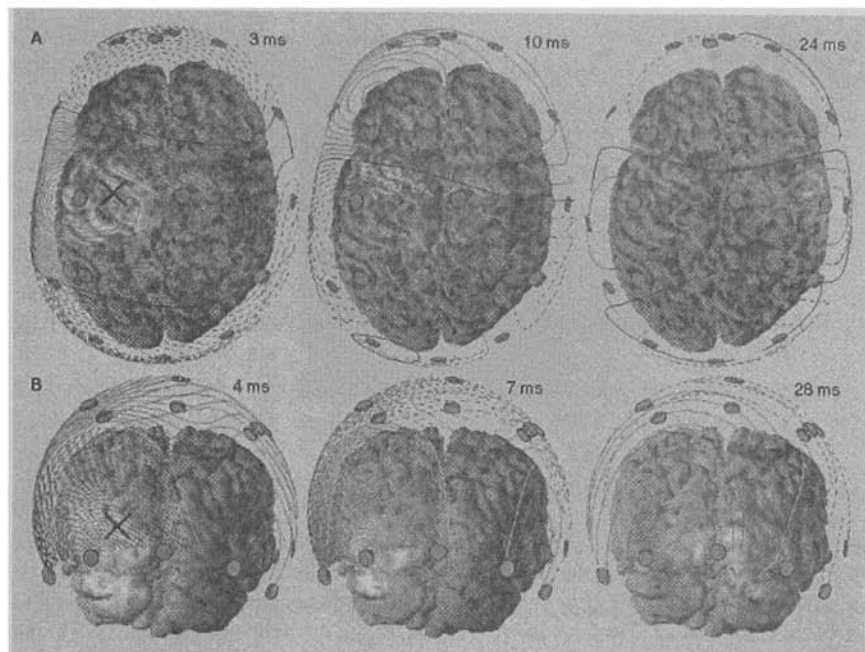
Activation maps based on TMS-evoked averaged EEG responses, subject JA. Minimum-norm estimates of the cortical activity are shown as color maps drawn on three-dimensional magnetic resonance images of the cortical surface of the same subject. The magnetic resonance images (MRIs) were acquired with a Siemens Vision 1.5-T system (Siemens, Germany) using a set of 1-mm-thick sagittal MPRAGE images (TR 9.7 msec, TE 4 msec, TI 20 msec, flip angle 10 degrees). In order to register the EEG data with the 3D MRI images, electrode and coil locations with respect to head landmarks were determined with a 3D digitizer pen (Polhemus, USA). Superimposed, the EEG is displayed as contour maps, with red lines indicating positive potential. The TMS coil position is indicated with a cross. L and R indicate the left and right hemispheres, respectively. (A) The response to left motor cortex stimulation. At latencies of 3 and 10 msec, the ipsilateral hemisphere shows prominent activation; at 24 msec, the contralateral activity dominates (between 10 and 24 msec, the two hemispheres showed simultaneous strong activation). The EEG contour spacing is 1 mV. (B) The response to visual-cortex TMS at 4, 7, and 28 msec poststimulus; the contour spacing is 2 mV. (From Ref. 24. Copyright © 2000 Lippincott Williams & Wilkins.)
